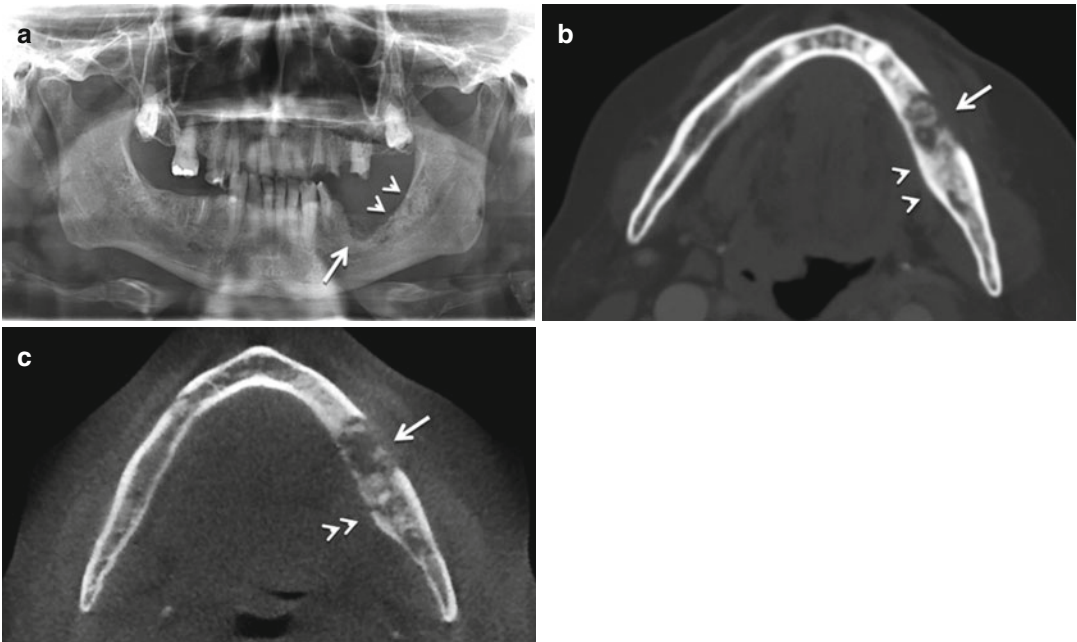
A 69-year-old male patient received intravenous bisphosphonate therapy with zoledronate (4 mg/month) due to osseous metastases from prostate carcinoma. (a) Panoramic radiograph. *Large arrow* is showing a radiolucent area corresponding to alveolar margin osteolysis. Posterior to the osteolysis, the *two arrowheads* depict osteosclerosis with disorganized medullary trabeculation and “cotton-wool”-like appearance. (b) Multislice
